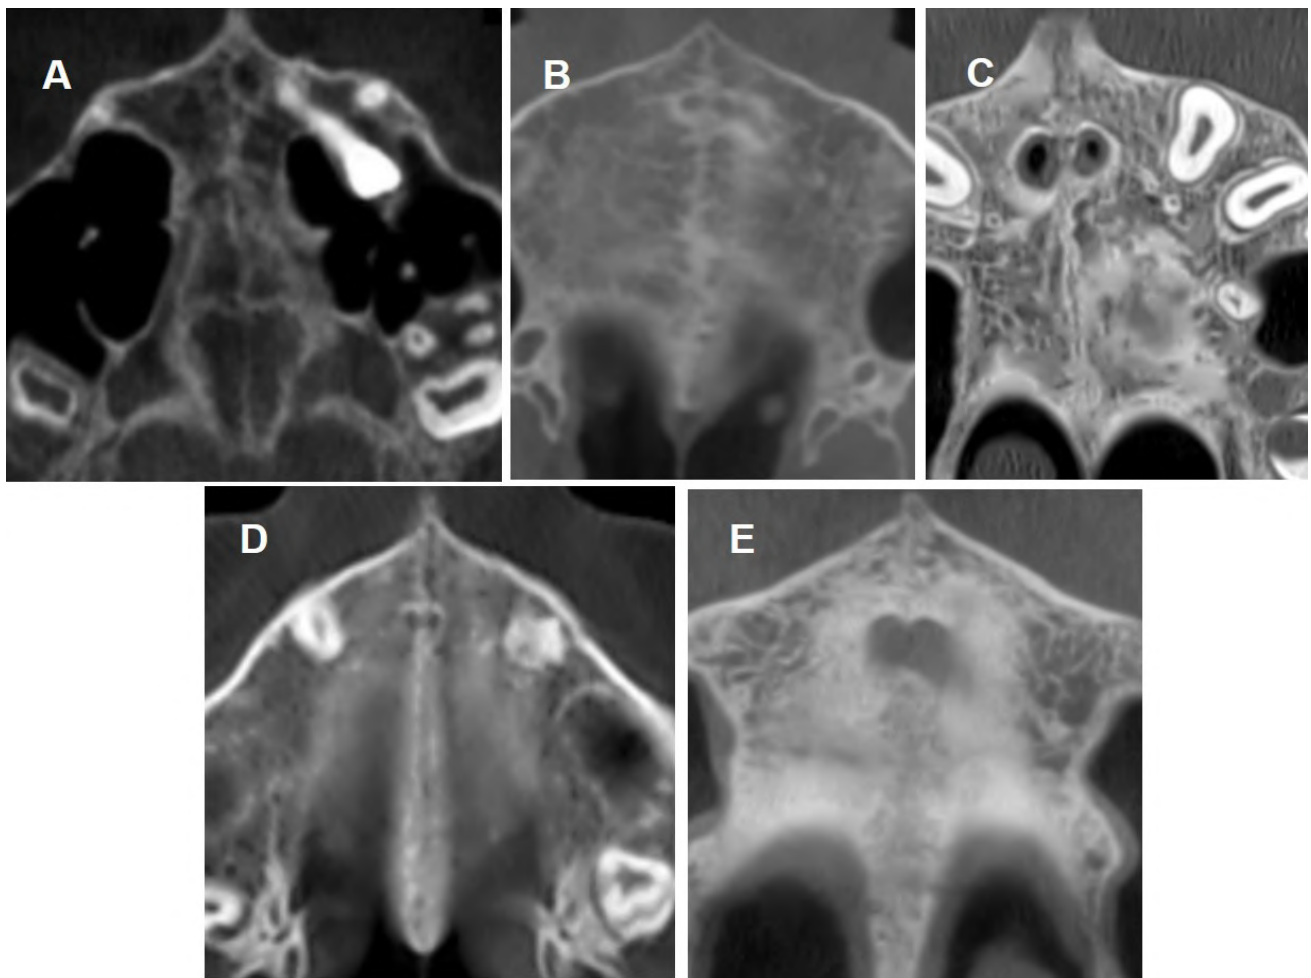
CBCT images of different stages in palatal maturation. A: shows straight line with high density. B: shows sutural lines with high density and toothed edge. C: two sutural lines with high density that are parallel to each other and a little distance with each other. D: complete ossification without observation of the sutural line. E: complete ossification of maxillary bone.
